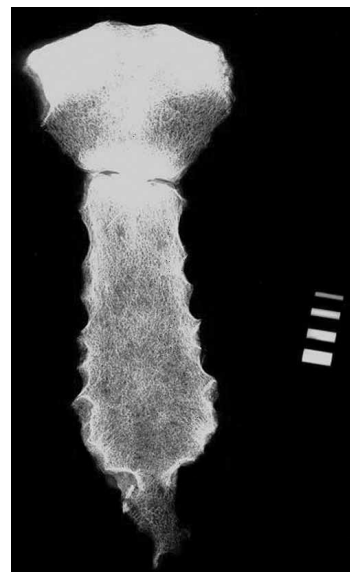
Depiction of bony trajectories in the X-ray of the sternum.
